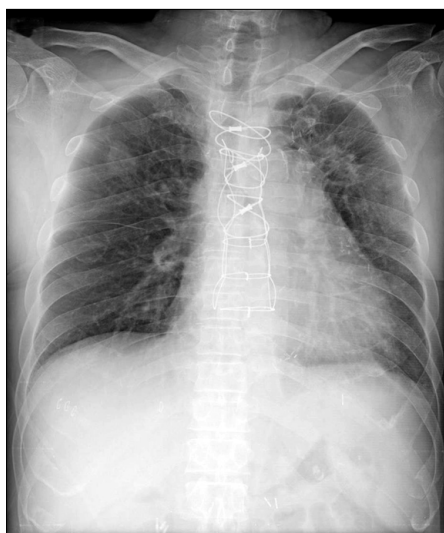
Simple chest radiography shows the Robicsek wiring technique for sternum revision due to sternal dehiscence following coronary arterial bypass grafting.
